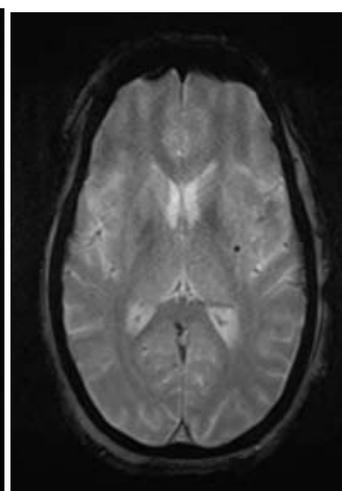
MRI Brain in T2 weighted image shows Bilateral Hyperintensities in caudate nucleus and putamen
